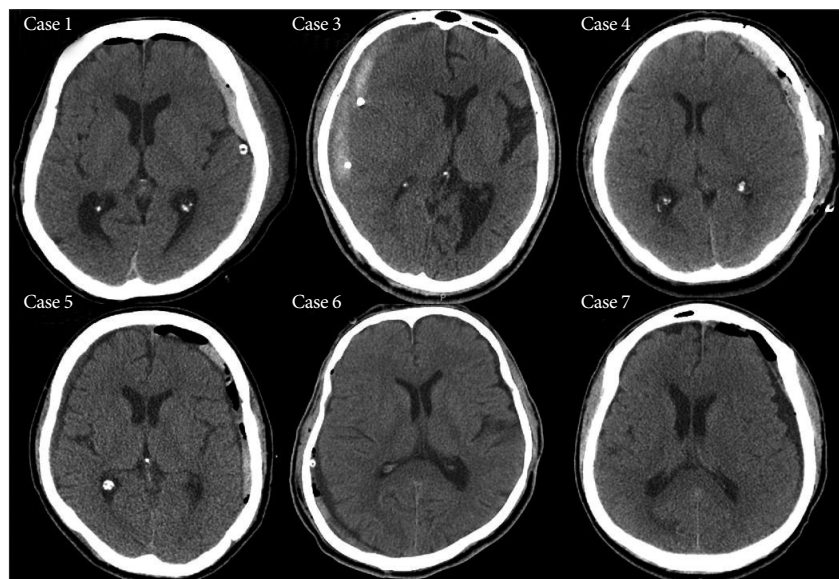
Immediate postoperative CT scans of the acute-on-chronic subdural hematoma. Even though some solid clots are remained, the degree of midline shift is reduced. In case 4, there is a thin acute hematoma after a craniotomy. In case 7, we could remove the semisolid clots clearly with endoscopy.
